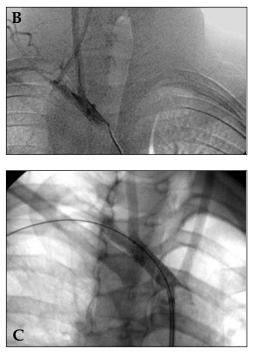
A pseudoaneurysm of the vertebral artery was noted on CTA after a gunshot wound to the neck, and a stent-graft was placed (inset). In this case, a 6 Fr, 90 cm sheath (Shuttle Select, Cook) was delivered via femoral puncture and positioned in the subclavian artery near the vertebral orifice. The balloon-expandable stent-graft (Atrium Medical) was easily delivered and deployed over a .018" wire (SV5, Cordis, Miami Lakes, FL).
